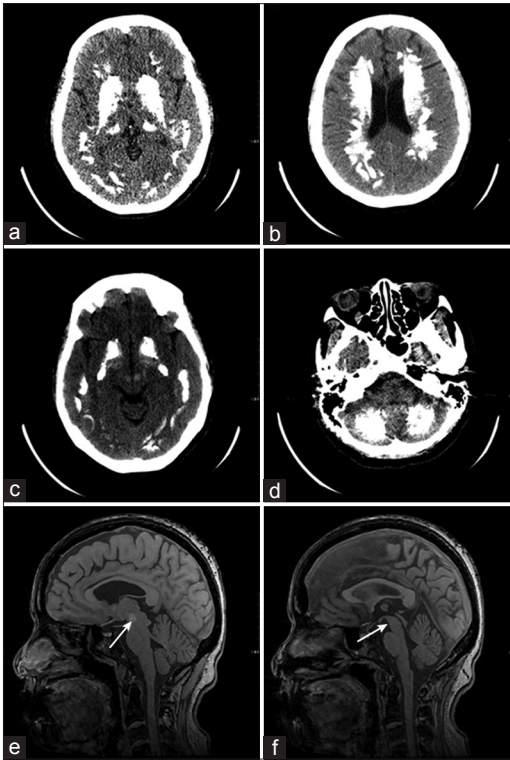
Computed tomography of the brain demonstrated extensive, bilateral calcification of basal ganglia, thalamus, centrum semiovale, midbrain, and cerebellum (a-d). Sagittal magnetic resonance imaging of the brain shows calcified deposits in midbrain and no atrophy in midbrain (e and f, arrows).
